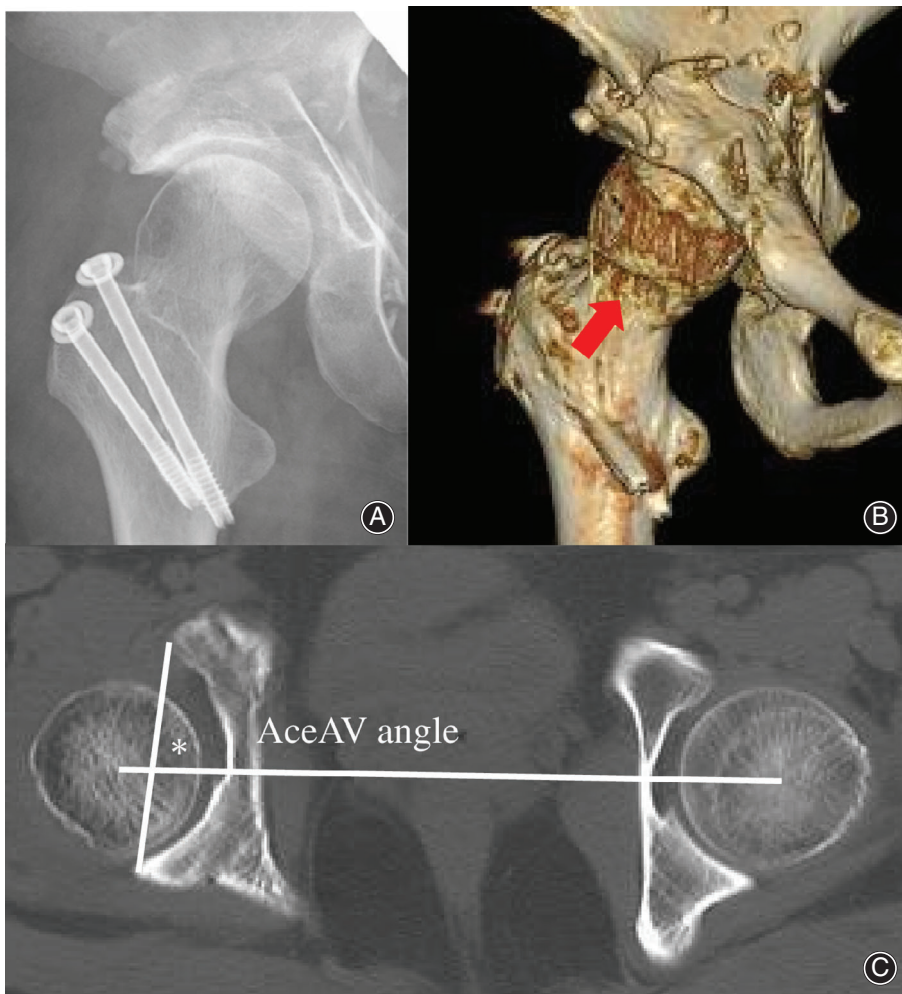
Postoperative radiographs and computed tomography (CT) images. (A) Image of the right hip joint showing improvement in coverage of the acetabulum, with a CE angle of 43° and an AHI of 93%. (B) Cam lesion resected from the right femur (indicated by the red arrow). (C) Axial CT images showing improvement in the acetabular anteversion angle from 1° retroversion to 9° anteversion in the right acetabulum CE, center angle; AHI, acetabular head index; AceAV angle, acetabular anteversion angle.
